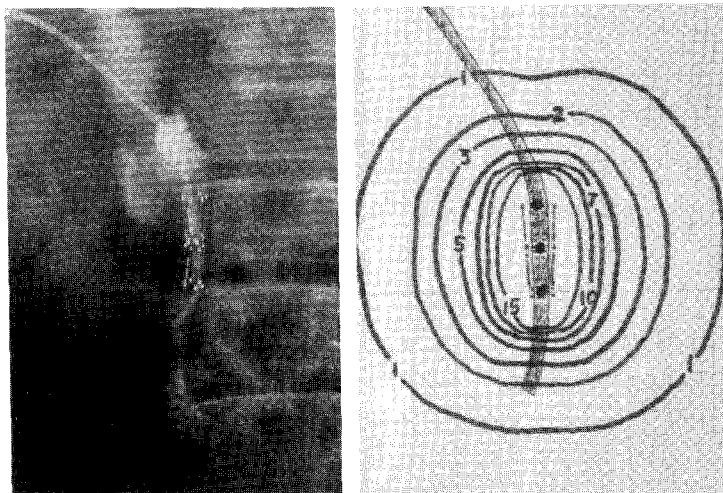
Intraluminal brachytherapy: high dose rate (HDR) Ir-192 remote control afterloading system (Gamma-Med 12i), left-abdominal X-ray after Gamma-Med tube insertion and right-dose planning after Gianturco stent insertion.
